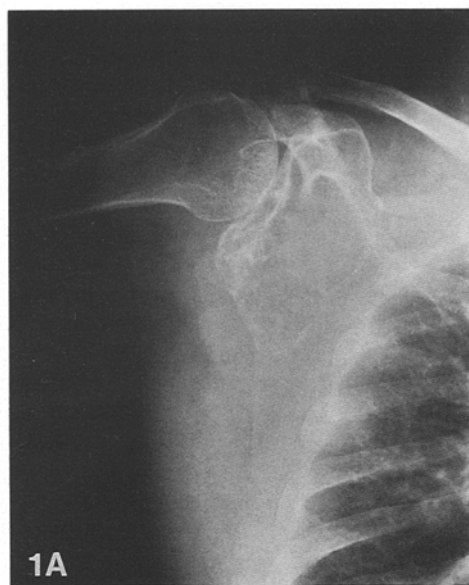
Plain AP and lateral roentgenograms demonstrate a sharply-defined, expansile, bubbly, radiolucent lesion involving the glenoid
